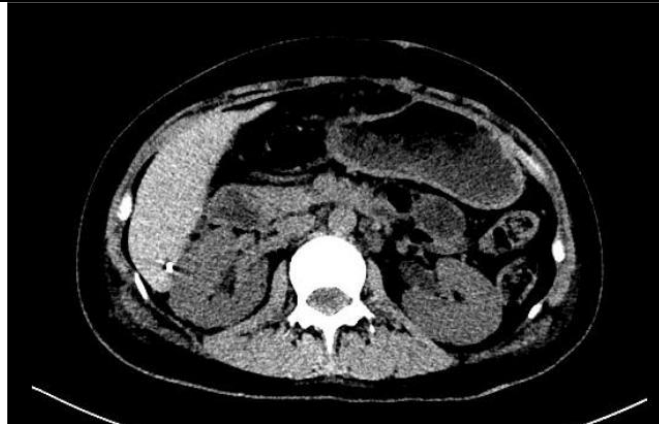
the abdominal CT scan after the surgery on April 28, 2024.
